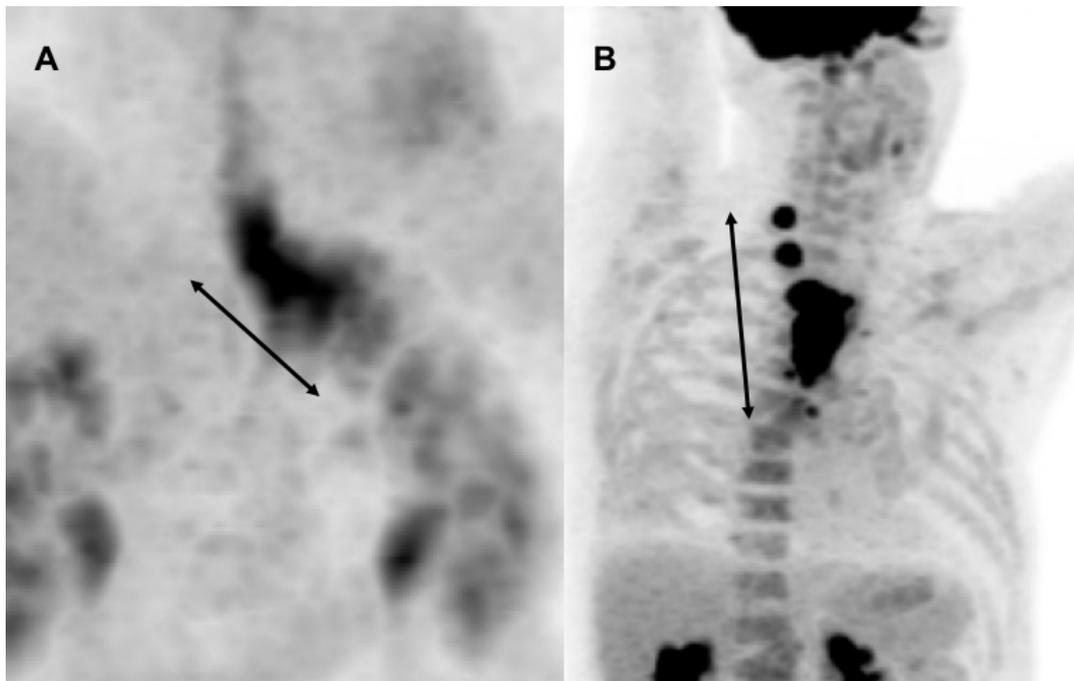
PET maximum intensity projection (MIP) images indicating measurements of MTL (A) and LoD (B). These selected images were obtained using a GE advantage windows 4.5 reporting workstation (GE Healthcare, Buckinghamshire, UK) and orientated to adequately represent the maximum dimension of MTL and LoD. Image A also demonstrates an 'avidity gradient' that can be seen in GOJ tumours involving the proximal stomach. FDG-avid LNMs seen in image B are included in the measurement of LoD.
